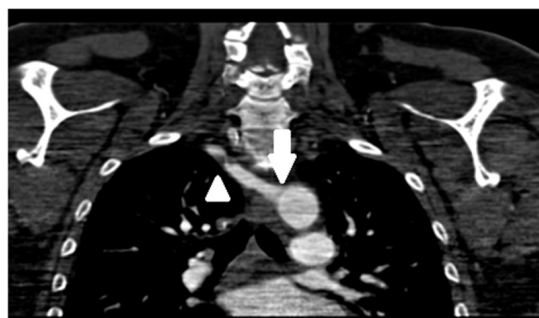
CT angiogram showing the aberrant origin of the right subclavian artery directly from the descending aorta (arrow) and the stenosis (triangle).
